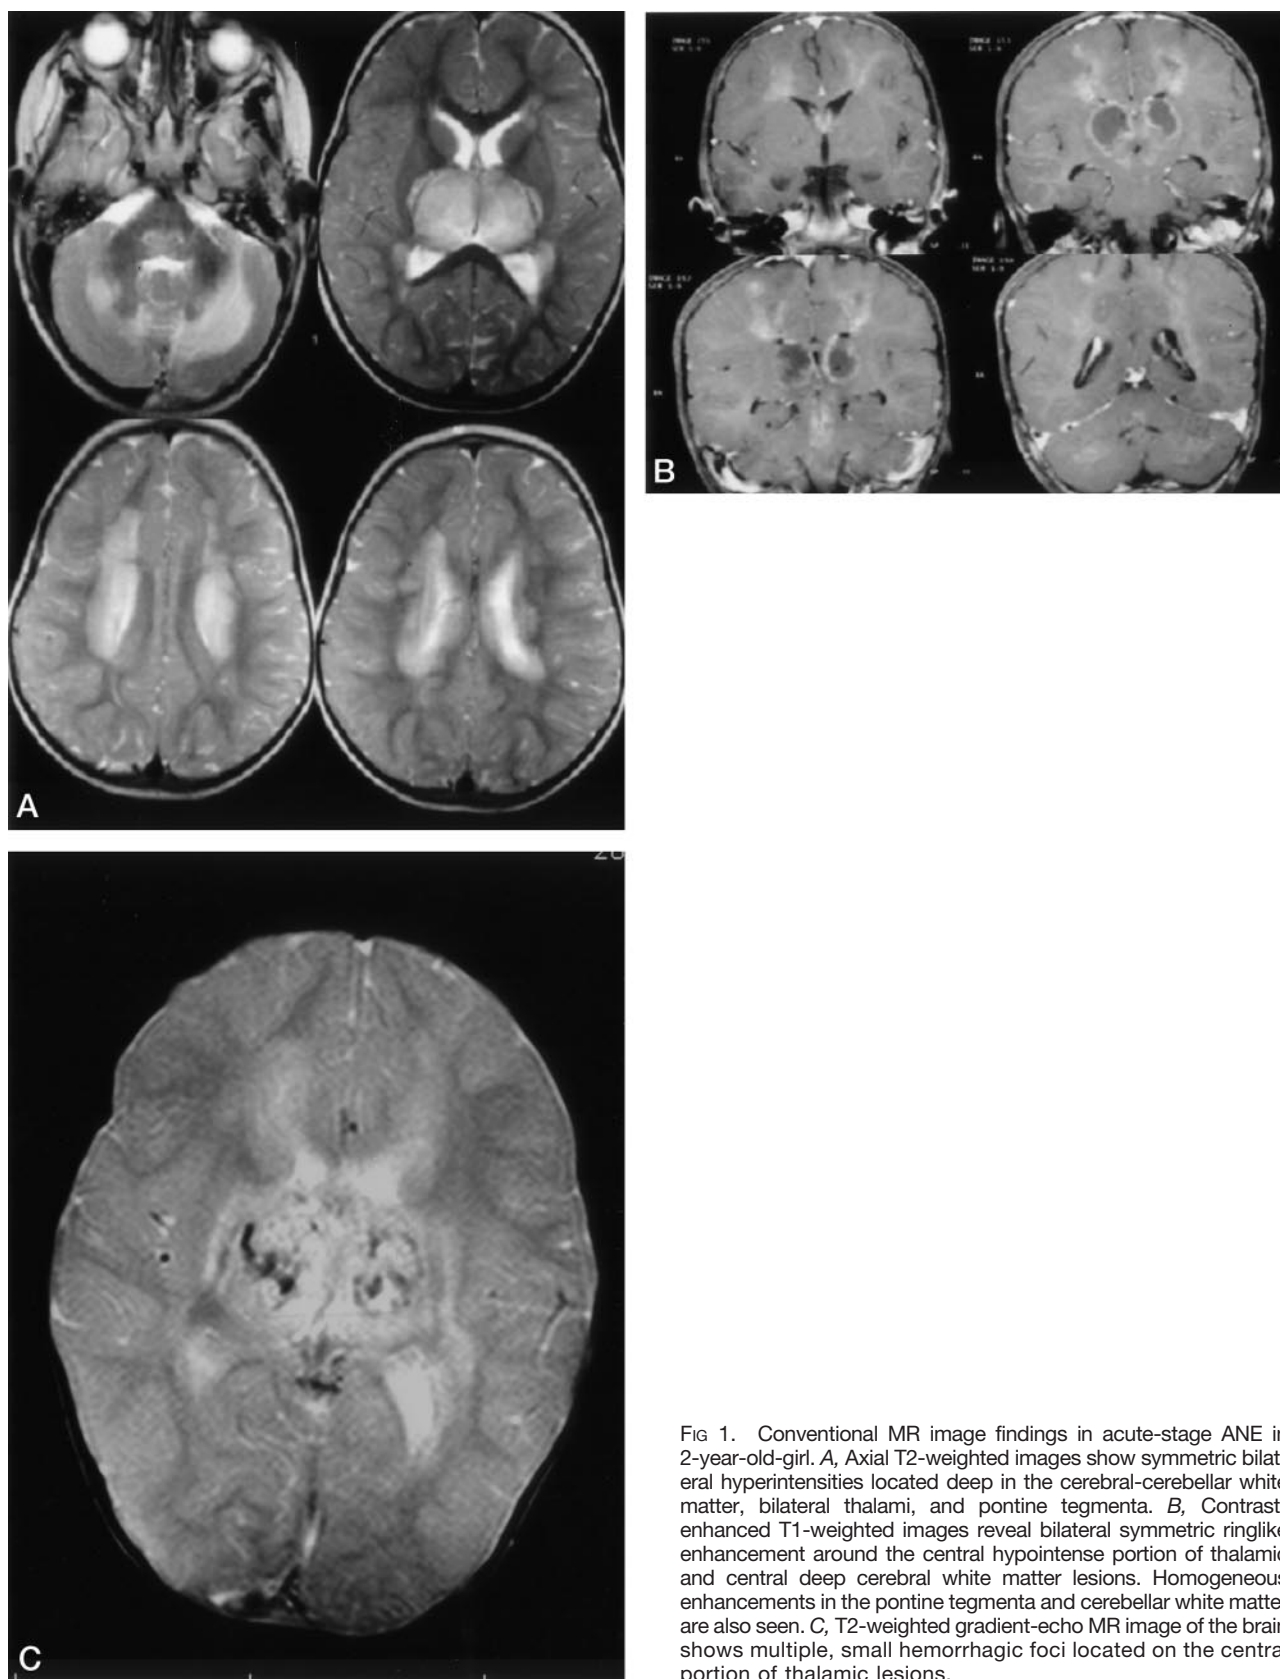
Conventional MR image findings in acute-stage ANE in 2-year-old-girl. *A*, Axial T2-weighted images show symmetric bilateral hyperintensities located deep in the cerebral-cerebellar white matter, bilateral thalami, and pontine tegmenta. *B*, Contrast-enhanced T1-weighted images reveal bilateral symmetric ringlike enhancement around the central hypointense portion of thalamic and central deep cerebral white matter lesions. Homogeneous enhancements in the pontine tegmenta and cerebellar white matter are also seen. *C*, T2-weighted gradient-echo MR image of the brain shows multiple, small hemorrhagic foci located on the central portion of thalamic lesions.
